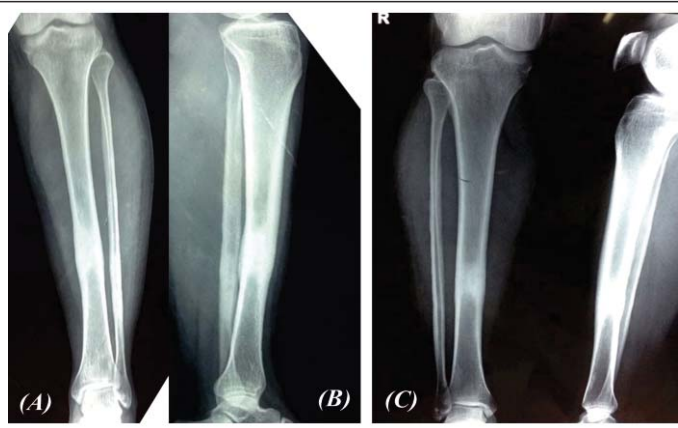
(A) Frontal and (B) lateral radiographs of the left and (C) frontal and lateral radiographs of the right tibia demonstrating bilateral cortical thickening and endosteal sclerosis. No periosteal reaction is seen.
